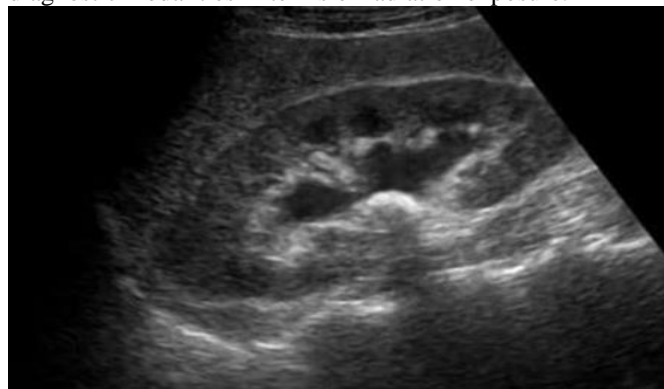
Ultrasound image shows an obstructing Calculus at PUJ
